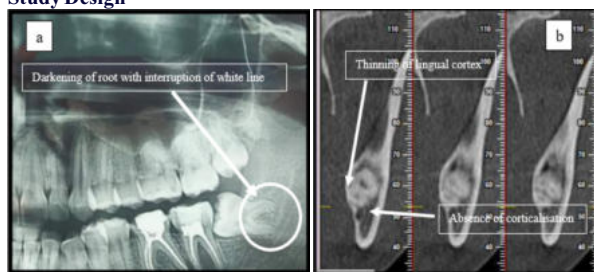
Comparison of (a) panoramic (OPG) features like darkening of the root and interruption of white line with (b) presence or absence of corticalisation of inferior alveolar canal (IAC) along with thinning of lingual cortical plate in CBCT
